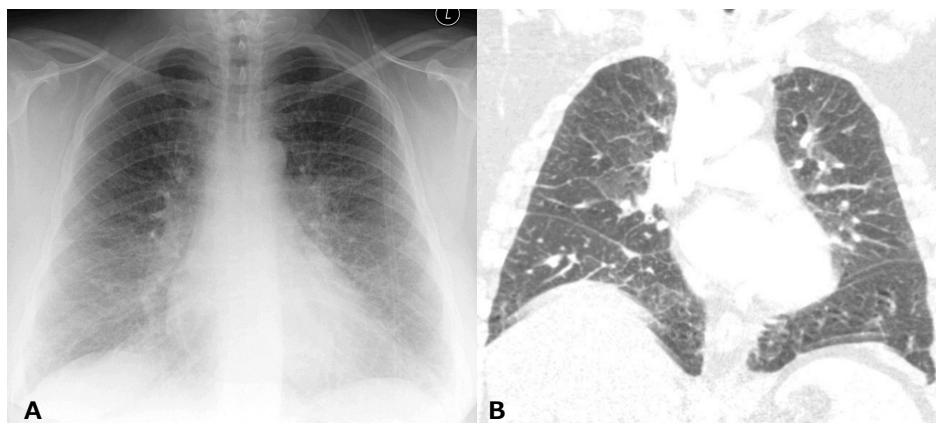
Chest X-ray (A) showing a diffuse interstitial pattern and a high resolution CT-scan (B) demonstrating thickened septa and patchy ground-glass opacities of a patient with drug-induced interstitial lung disease associated with nitrofurantoin.
